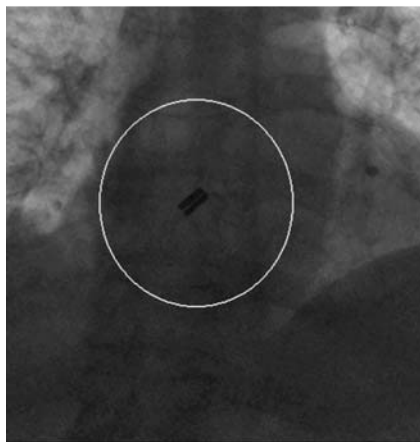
Radiographic image showing the magnets in position and attracted to each other to form a neo-septum.
